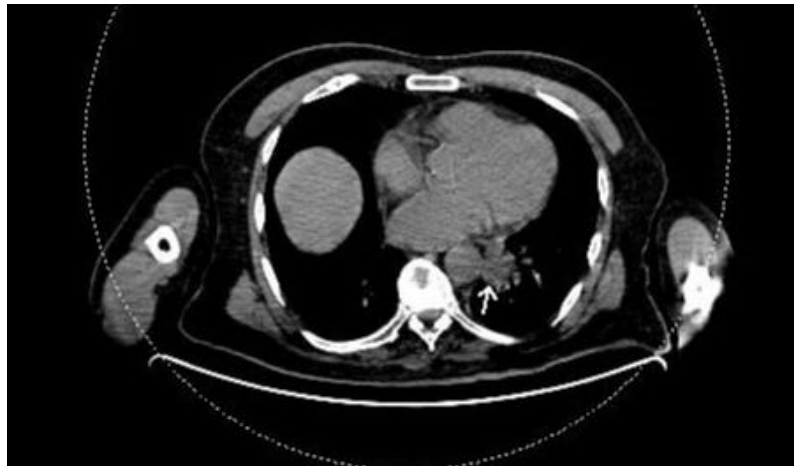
Torax CT showed solid lung mass.
